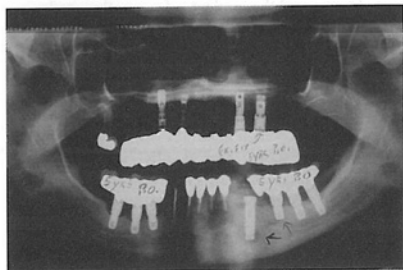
Five years following prosthesis placement, the patient reports screw loosening, significant occlusal wear resulting from parafunctional habits, and radiographic evidence of bone loss around the implants.
